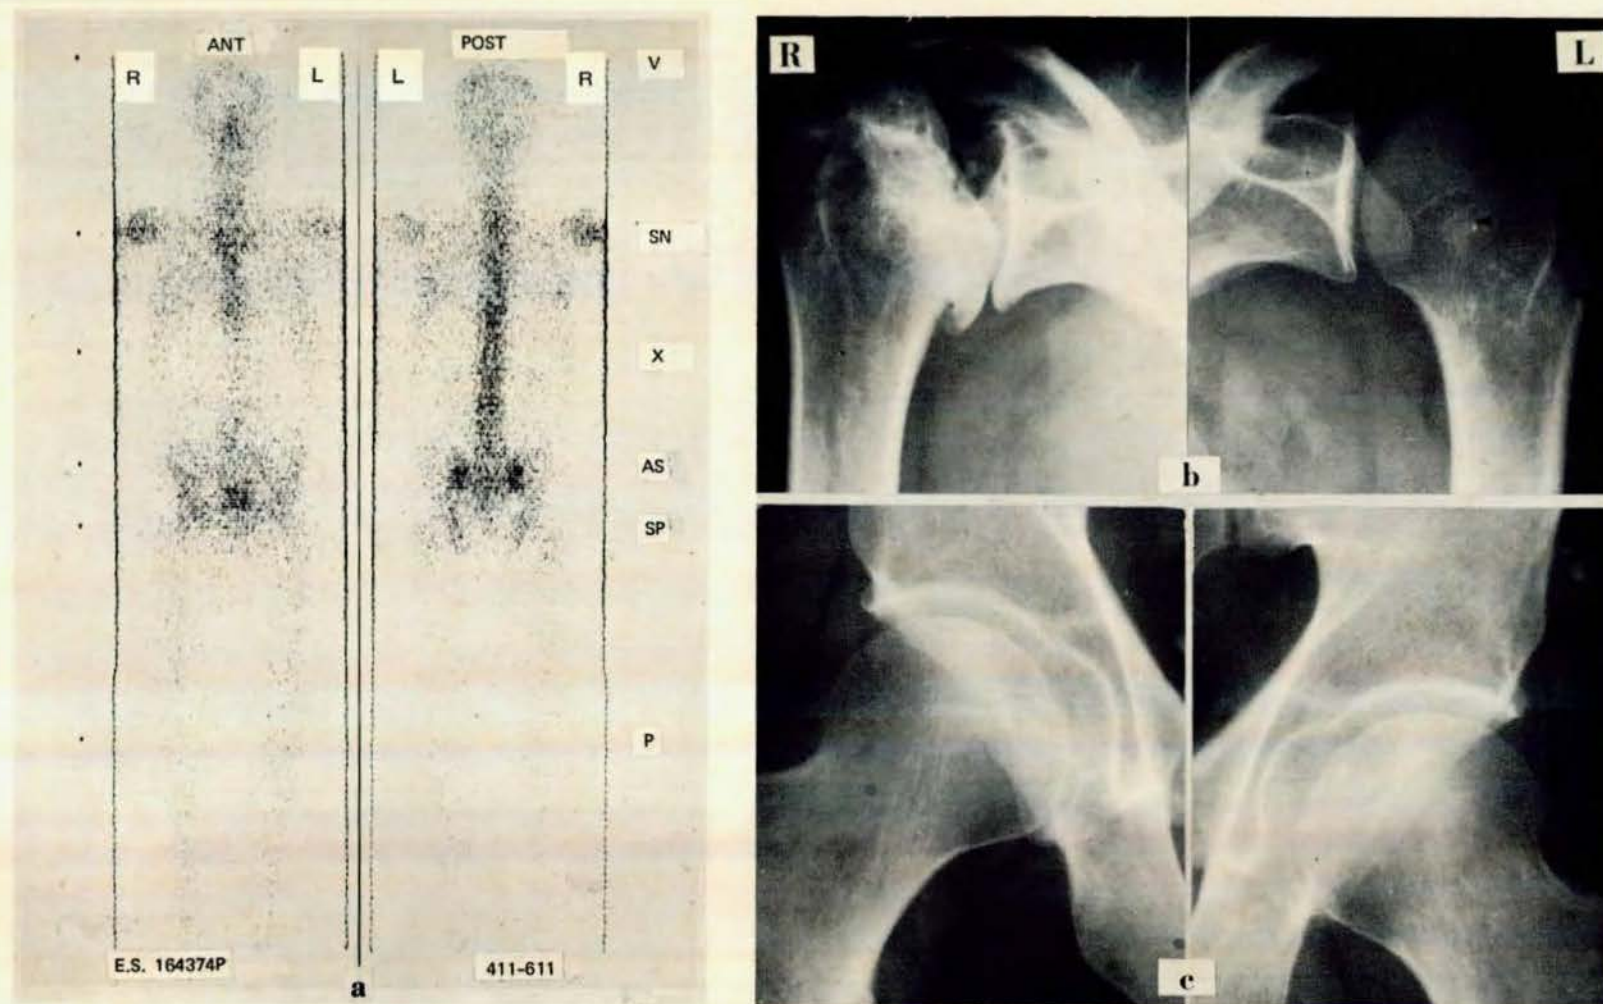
(a) Anterior and posterior total-body survey scans of diver begun 2 hr after an intravenous dose of 2.8 mCi of Na^{18}F . Note abnormal areas of increased tracer concentration in R shoulder and in region of R femoral head and/or R ilium. (Abbreviations for anatomic levels: V, vertex; SN, suprasternal notch; X, xiphoid process; AS, anterosuperior iliac spine; SP, symphysis pubis; P, patella.) (b) Shoulder radiographs with arrow pointing to abnormally dense area in L humeral head. This area of old osteonecrosis did not appear on radionuclide scans. (c) Hip roentgenographs reveal no abnormalities.
